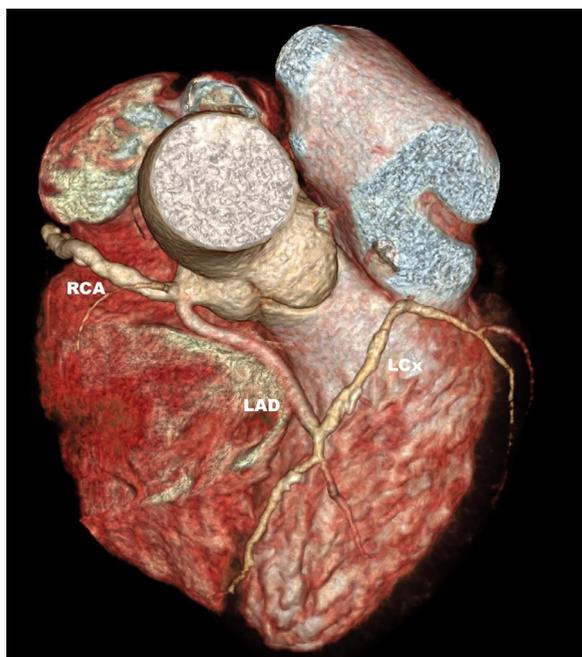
Single coronary artery (SCA) type Lipton type R 2B. Coronary computed tomography angiography, volume-rendered reconstruction shows a SCA originating from the right sinus of Valsalva. LAD=left anterior descending artery; LCx=left circumflex artery; RCA=right coronary artery.
